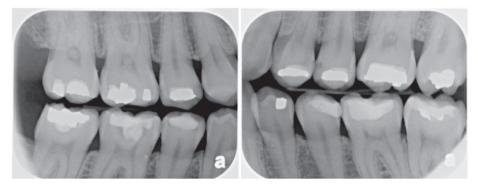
The bitewing views.
